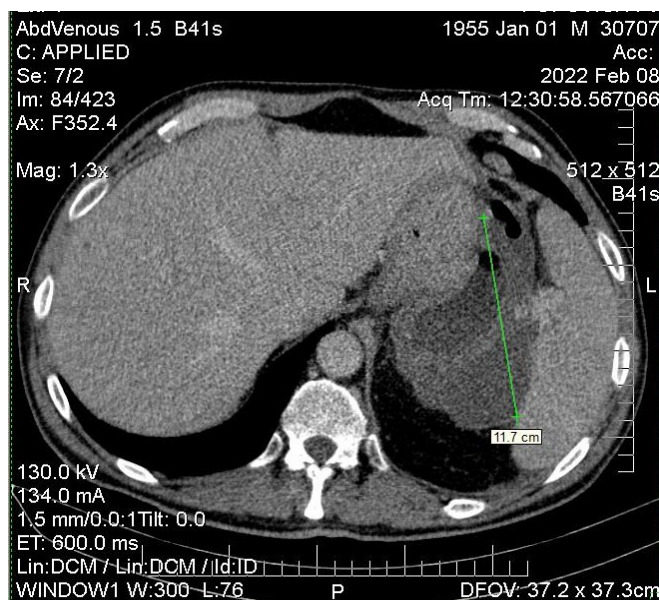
CT data 08.02.2022, tumor 112x93x90 mm
